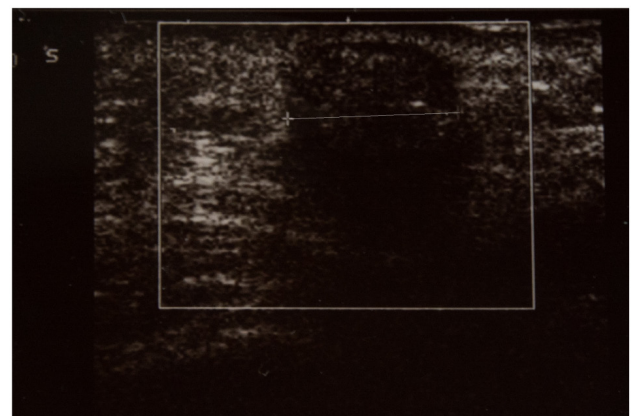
Ultrasound examination of pilomatrixoma revealed an oval-shaped, subcutaneous, well-defined, hypoechoic tumor ~10 mm in diameter.
